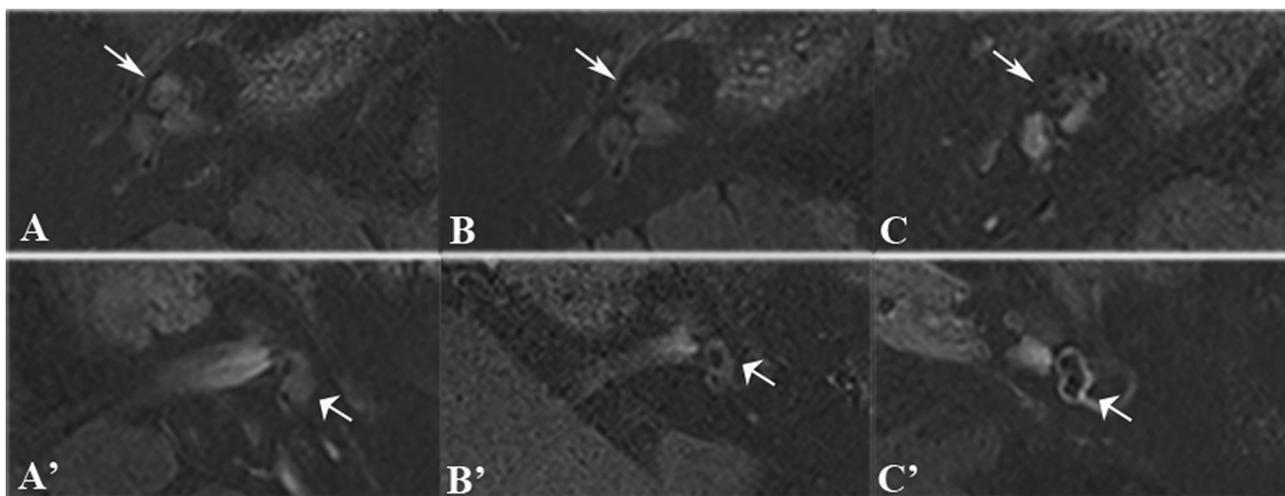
3D-real IR MRI scans of patients with different degrees of ELH. A–C, images of cochlear ELH. A, No ELH in cochlea, B, moderate ELH in cochlea, C, significant ELH in cochlea; A'–C', images of cochlear ELH. A', No ELH in vestibule, B', moderate ELH in vestibule, C', significant ELH in vestibule. Cochlea (thin arrows) and vestibule (broad arrows).
